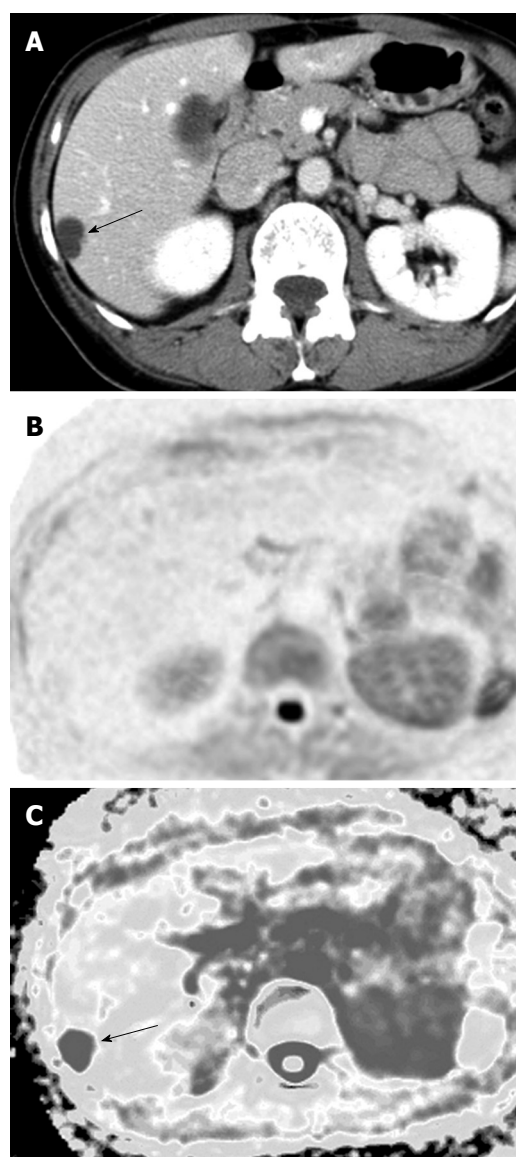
A case of hepatic cysts. A: Dynamic computed tomography in the portal phase showing the hepatic cyst as a low-density lesion (arrow); B: The lesion expressed no signal intensity on diffusion-weighted imaging; C: The lesion showed a high apparent diffusion coefficient (ADC) on the ADC map (arrow).
